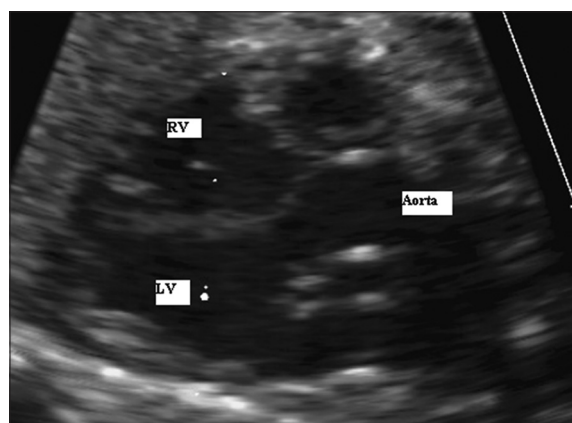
Fetal echocardiogram at 27 weeks of gestation 2D shows absence of the aortic valve and dilated aorta. Left ventricle. Right ventricle
